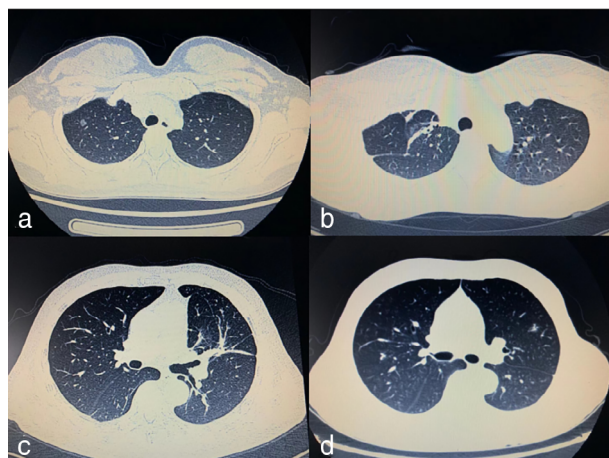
(a) The preoperative lung CT scan for $RS^1+S^2b+S^3a$. (b) The postoperative lung CT scan for $RS^1+S^2b+S^3a$ after 3 months. (c) The postoperative lung CT scan for $LS^3+S^{1+2}c+S^{1+2}a+b^1$ after 3 months. (d) The preoperative lung CT scan for $LS^3+S^{1+2}c+S^{1+2}a+b^1$. Arrows mark pulmonary nodules
